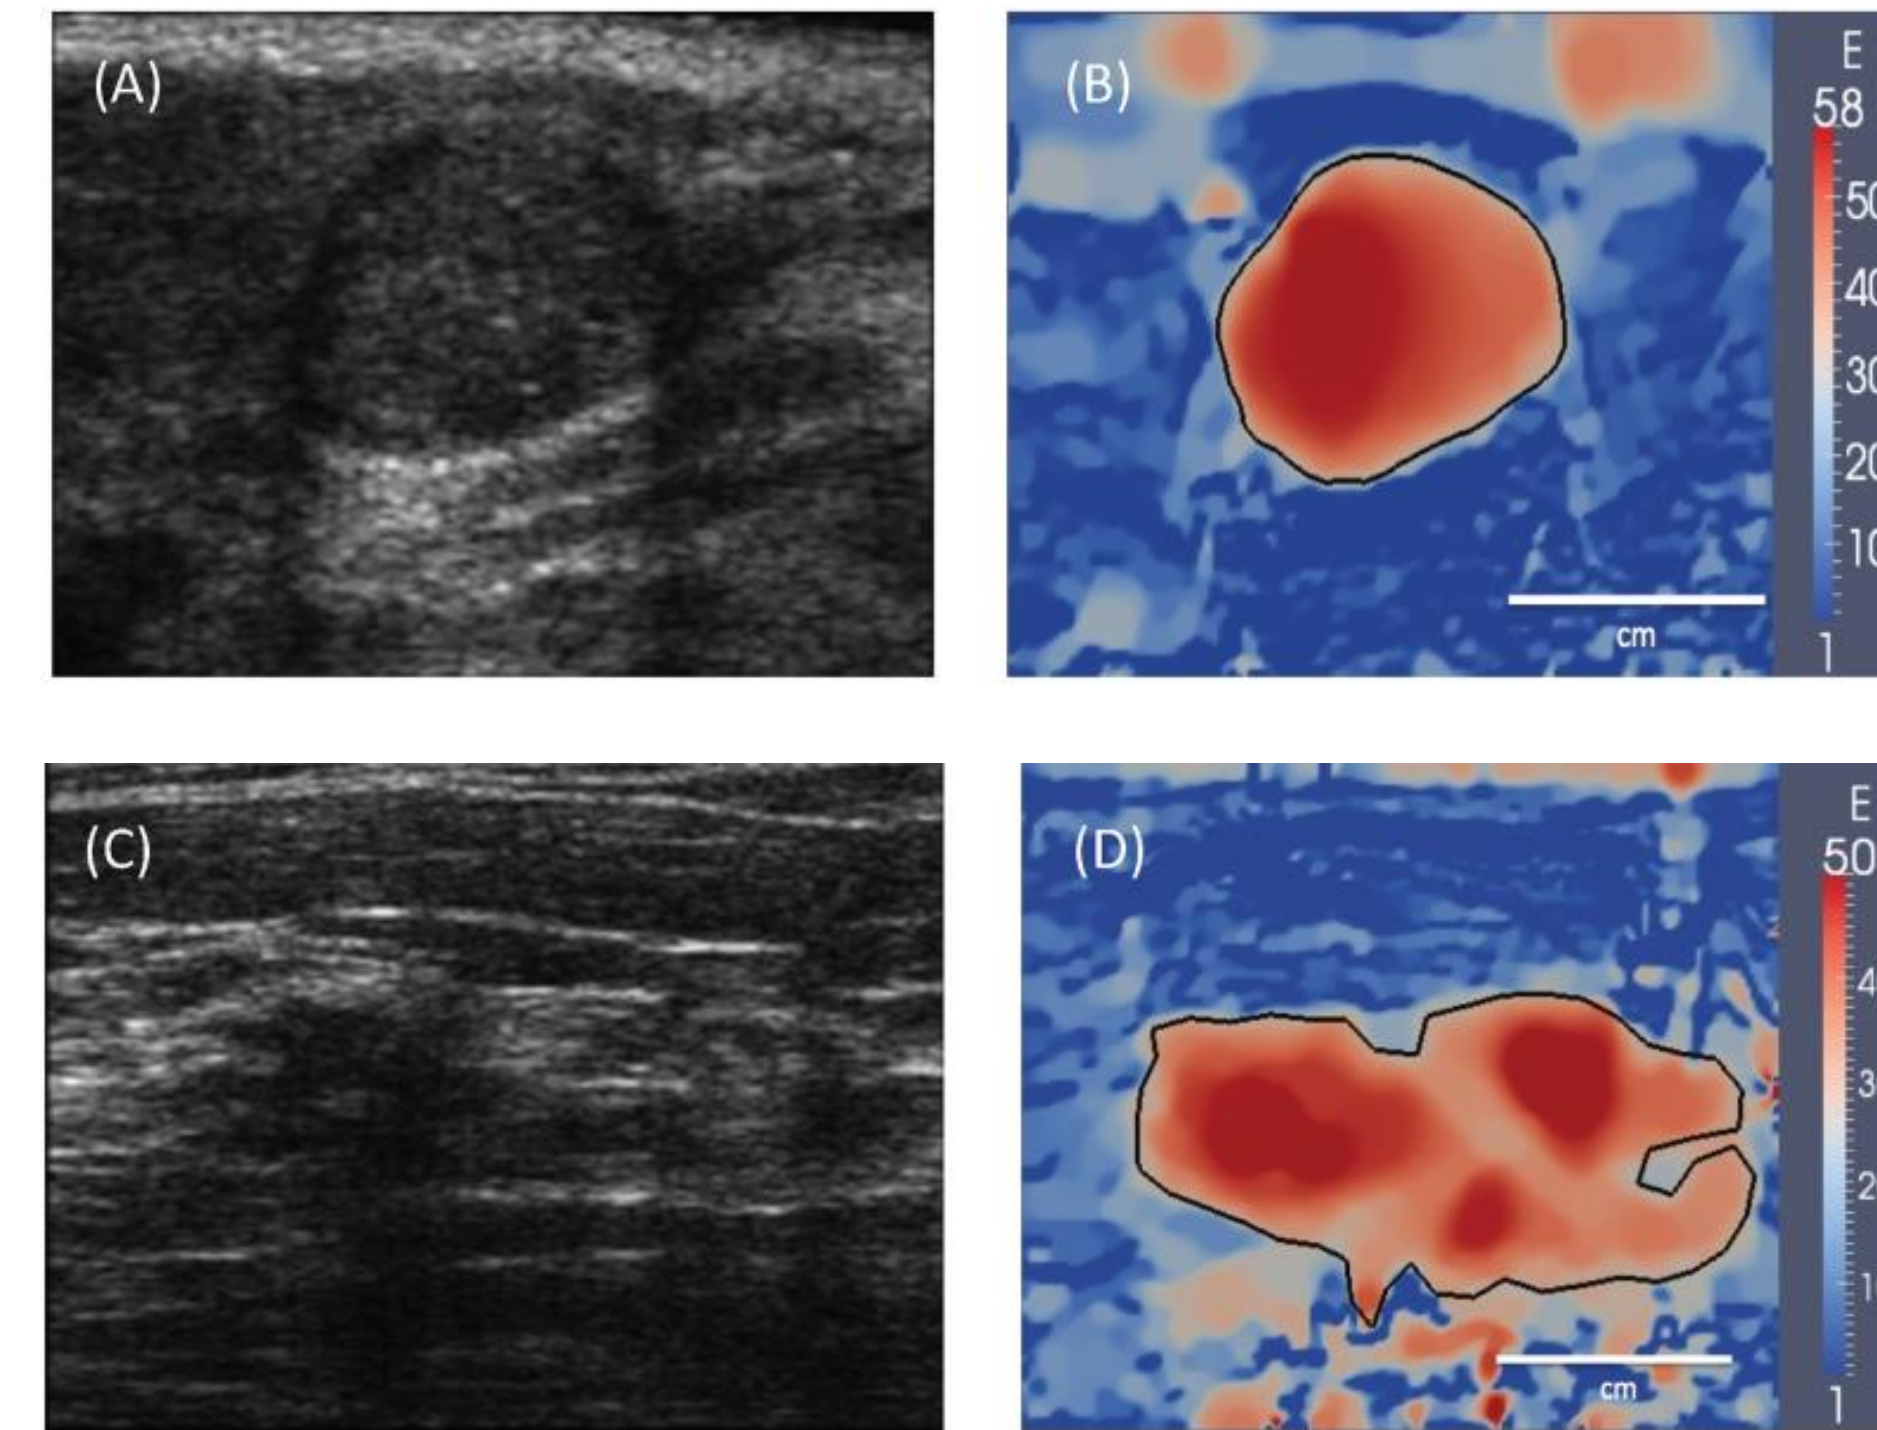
Ultrasound imaging of a homogenous (A, B) and a heterogeneous (C, D) fibroadenoma. Adapted from Liu et al.<sup>[8]</sup>
